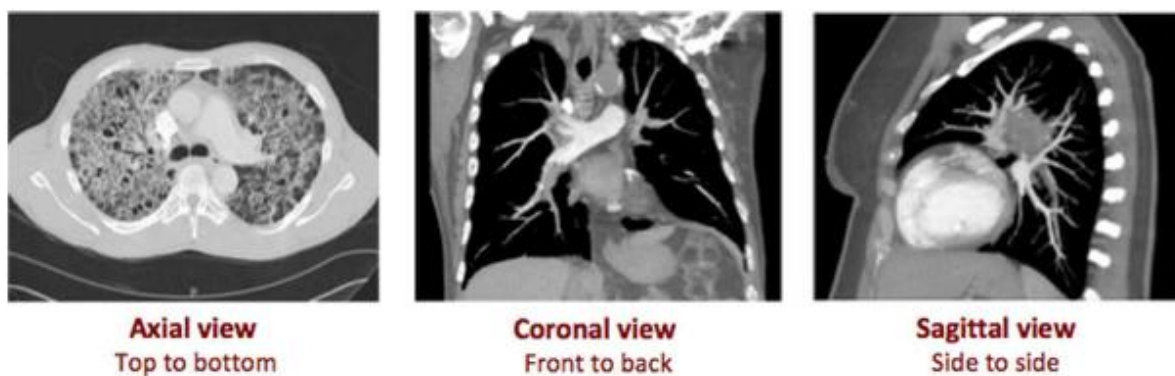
Anatomical views of a HRCT scan [21].
